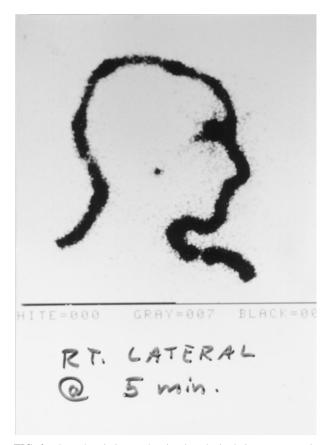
Lymphoscintigram showing lymphatic drainage patterns in the parotid region.
